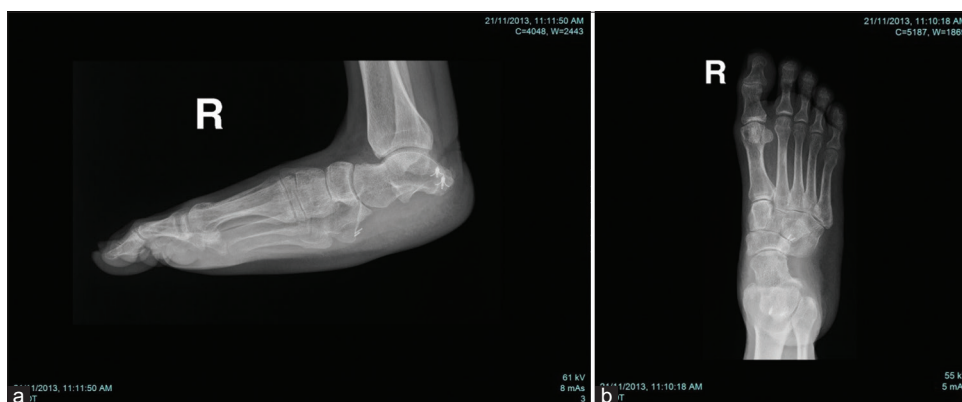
Radiographs at follow-up after 8 years (a) lateral view and (b) anteroposterior view.
